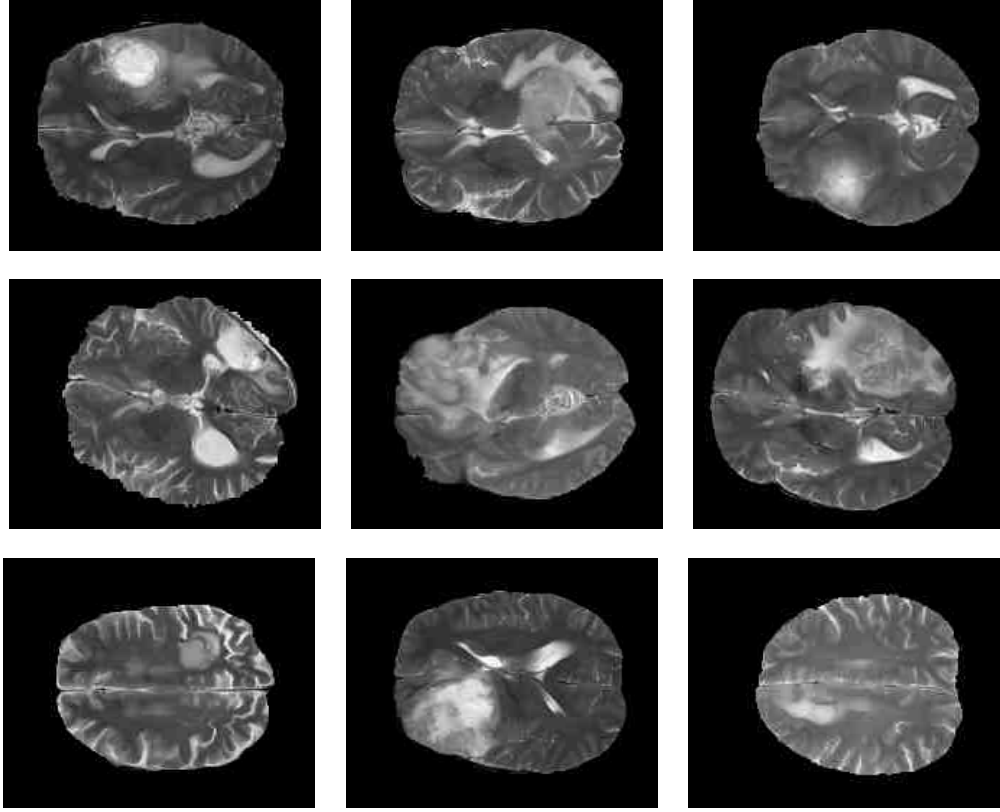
Examples of real T2-weighted MR images
